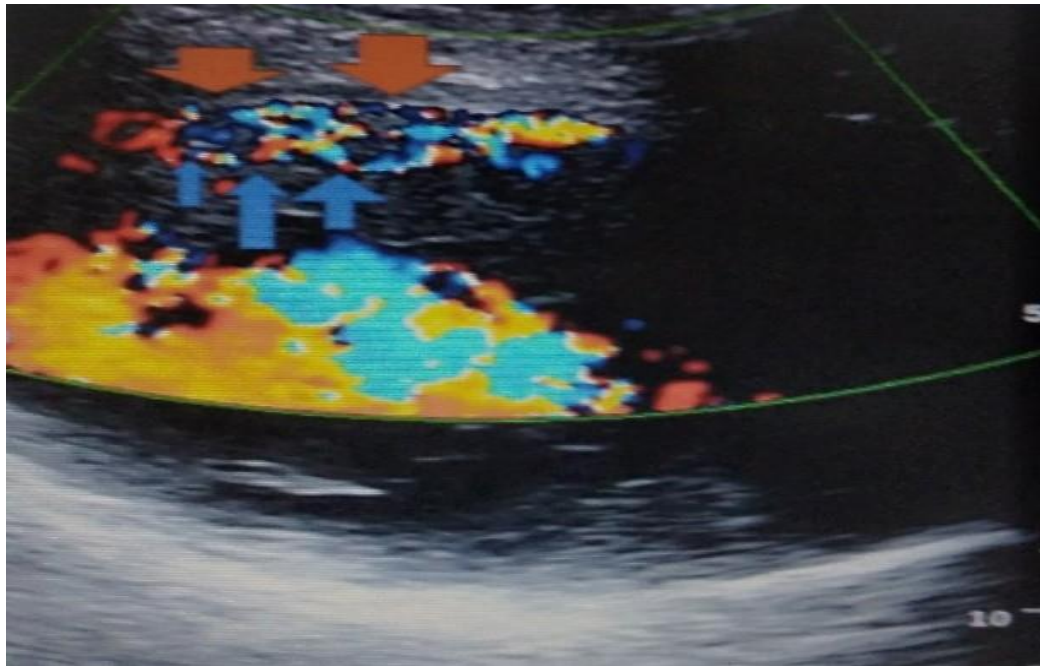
Long parasternal view of left anterior descending coronary artery, shows multiple stenosis and rescuing vessels or proximal collateral vessels, red arrows pointing to severe stenosis to obstruction of the original LAD-CA, and blue arrows pointing to stenosis of the collateral vessels, in between left red and blue arrows there are three arteries; original, first and second collateral, and in between the right; one red and two blue arrows, also there are three arterial parts; one original and two collaterals.
